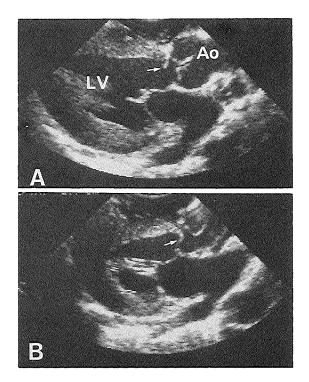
Left ventricular long-axis view (A, B) obtained intraoperatively with the transducer placed onto the right ventricular surface, The patient was known to have a subaortic membrane. Preoperative echocardiographic investigation, however, had left doubt whether the interventricular septum showed characteristics of a hypertrophic obstructive cardiomyopathy. The echocardiographic images revealed left ventricular hypertrophy and a discrete subaortic membrane closely to the right aortic valve (arrow). No evidence was found of hypertrophic cardiomyopathy. Ao = aorta; LV = left ventricle.
